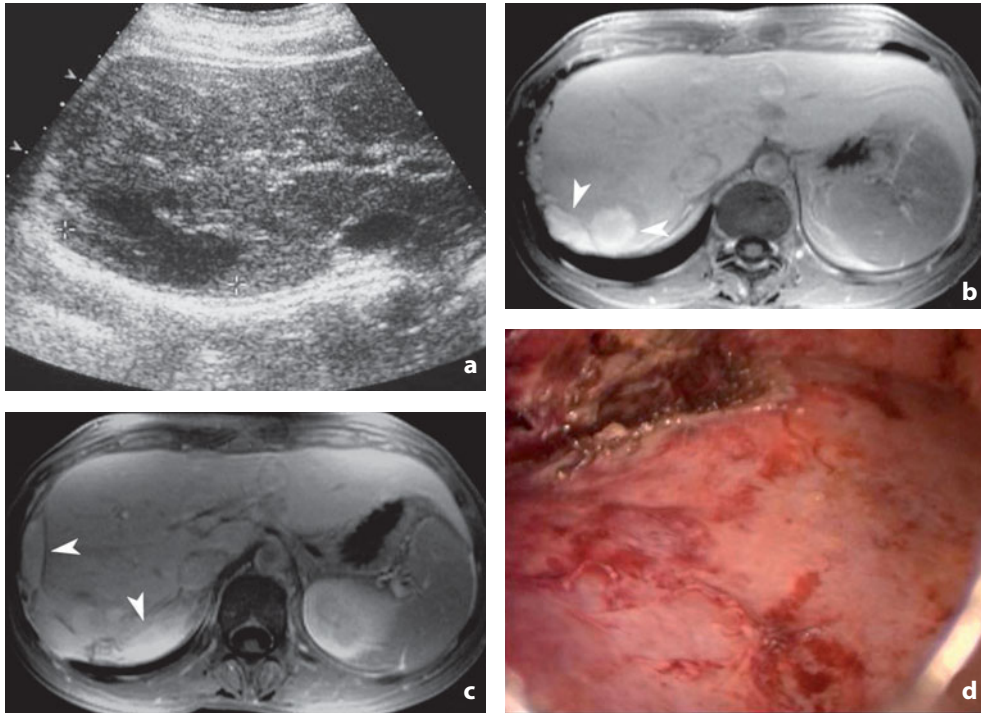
Ultrasonography and magnetic resonance. Hepatic endometriosis. a Sonogram shows hypoechoic subcapsular areas in the posterior sectors of the right lobe (*crosses*). The T1-weighted MR sequences with fat signal saturation (b, c) confirm the presence of hyperintense confluent hemorrhagic collections (*arrowheads*) with capsular and subcapsular location and confirmed at laparoscopy (d) as endometrial implants
